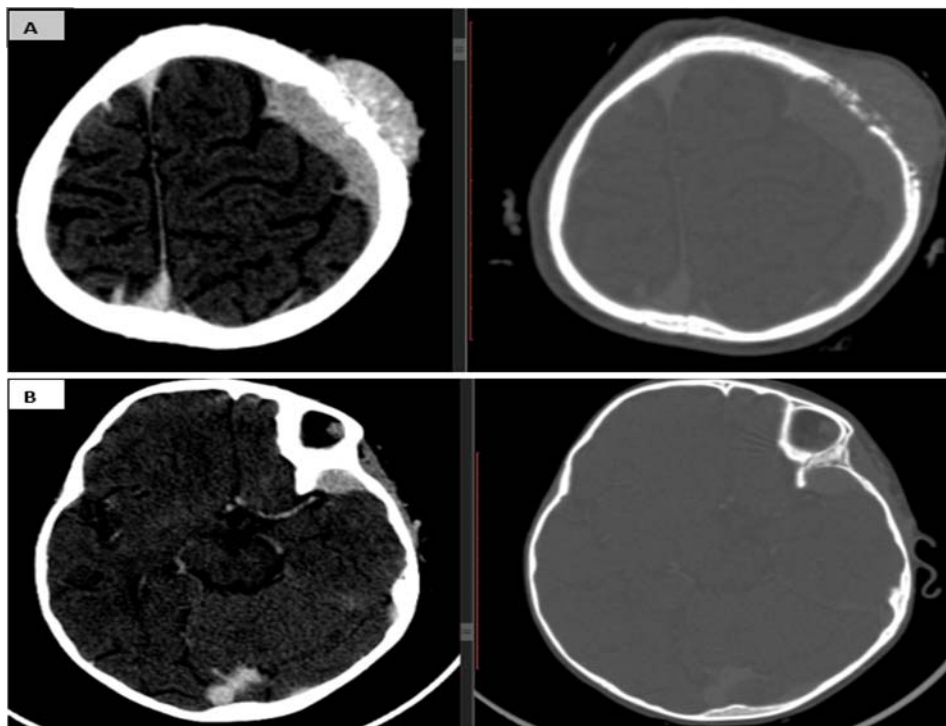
Contrast enhanced head CT (A & B): lytic permeative lesion involving the left parietal and posterior left frontal bones with associated heterogeneous soft tissue mass overlying scalp soft tissue swelling as well as underlying extra axial soft tissue mass (A). There is also lytic permeative lesion on the greater wing of the sphenoid bone adjacent to the left superior orbital fissure with associated extra axial soft tissue mass (B).
